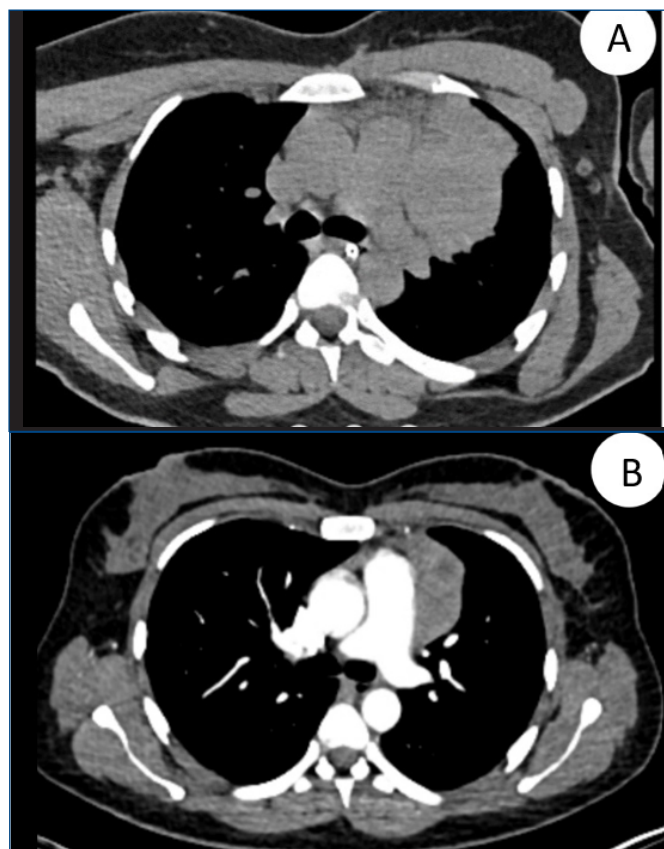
(A): 76 x 53 x 88 mm soft tissue lesion in the prevascular region in the anterior mediastinum on thorax CT (B): 63 x 30 x 63 mm soft tissue lesion showing regression on thorax CT taken 18 days later
